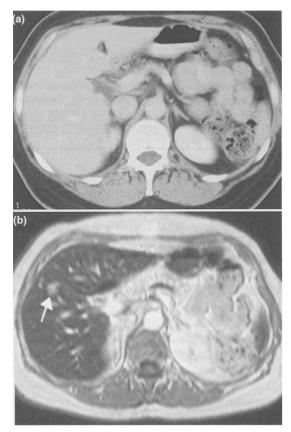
(a) The CT scan shows no abnormality. (b) Following SPIO administration, the signal intensity of liver is diminished, which renders visible a liver metastasis as a focal high-signal-intensity lesion (arrow).
